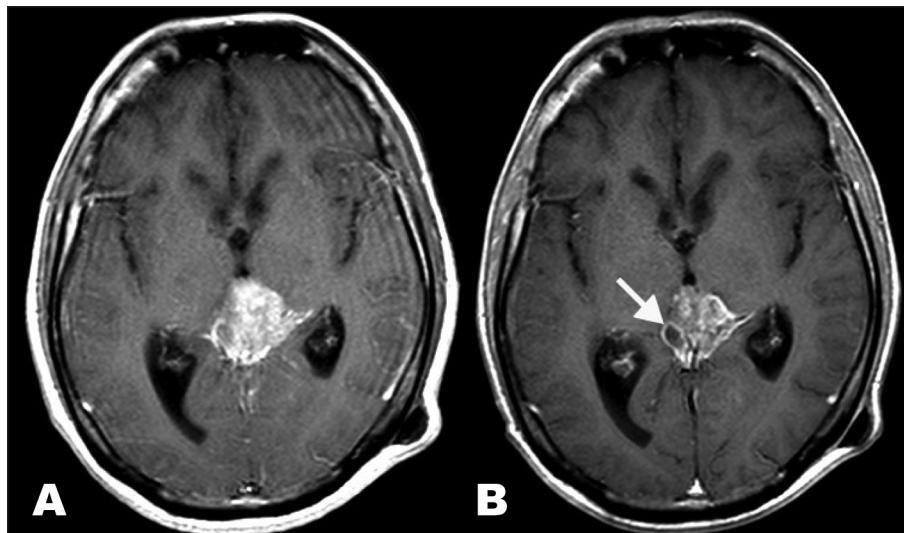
T1-weighted MR image pre-treatment (A) shows an enhancing pineal mass. The post-treatment T1-weighted MR image (B) demonstrates the pineal region mass with heterogeneous enhancement, presenting areas suggestive of necrosis (arrow).
